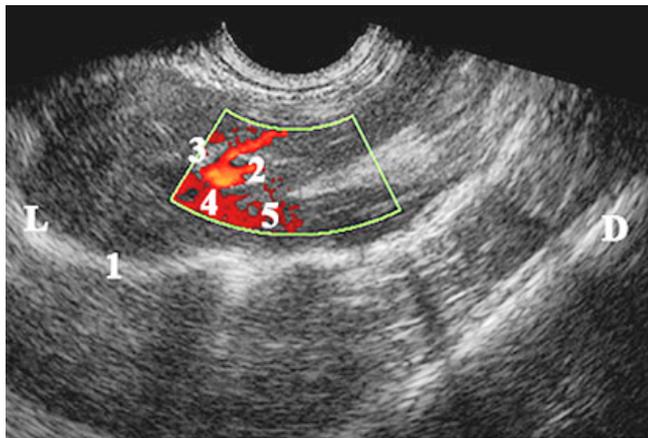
Color Doppler US image of gall bladder (sagittal section, color and pulse Doppler transducer – 7.5 MHz). L – left; D – right. (1) diaphragm and fibrous capsule; (2) gall bladder fund; (3) body of gall bladder; (4) infundibulum and neck of the gall bladder; (5) cystic duct
